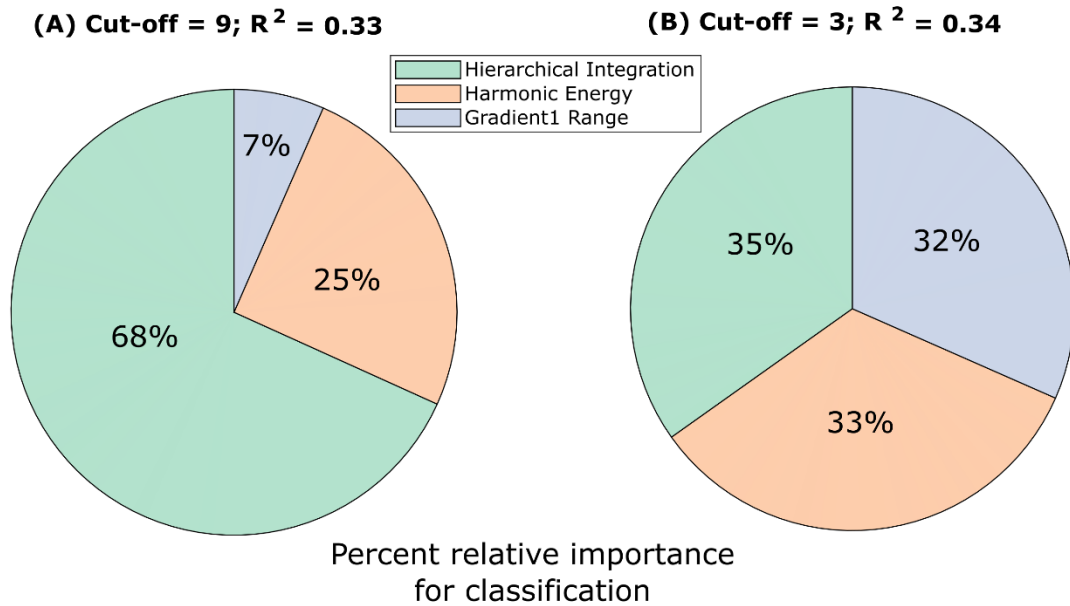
Dominance analysis for classification of arousal scores based on different cut-off values, from the combined Multi-Anaesthesia and DBS datasets. (A) Cut-off of 9 separates wakefulness and high-amplitude CT stimulation from all other conditions. (B) Cut-off of 3 separates wakefulness and both high- and low-amplitude CT stimulation, from anaesthesia with different drugs and VT stimulation. Pie charts represent the percentage of relative importance of each predictor from dominance analysis.
